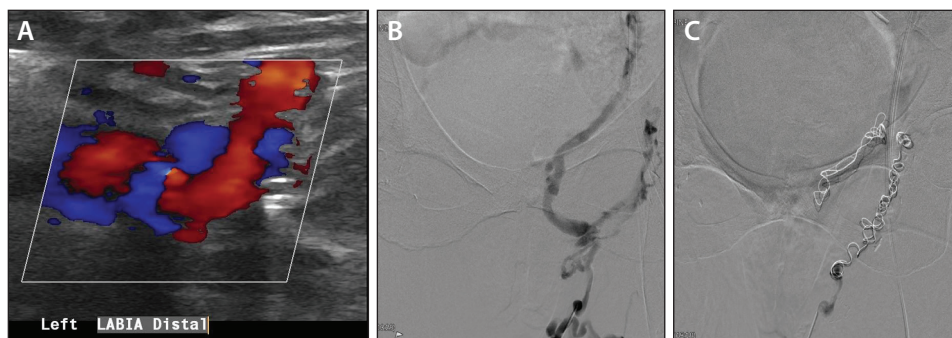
Residual pelvic floor/labial varices. Perineal ultrasound of large left paralabial varices (A). Direct stick venogram of deep left labial varices accessed under ultrasound with two large draining veins, the obturator and gluteal veins to the presacral plexus (B). Postmicroselection from the internal iliac vein with coil embolization and subsequent administration of 1.5% sodium tetradecyl foam (C).
